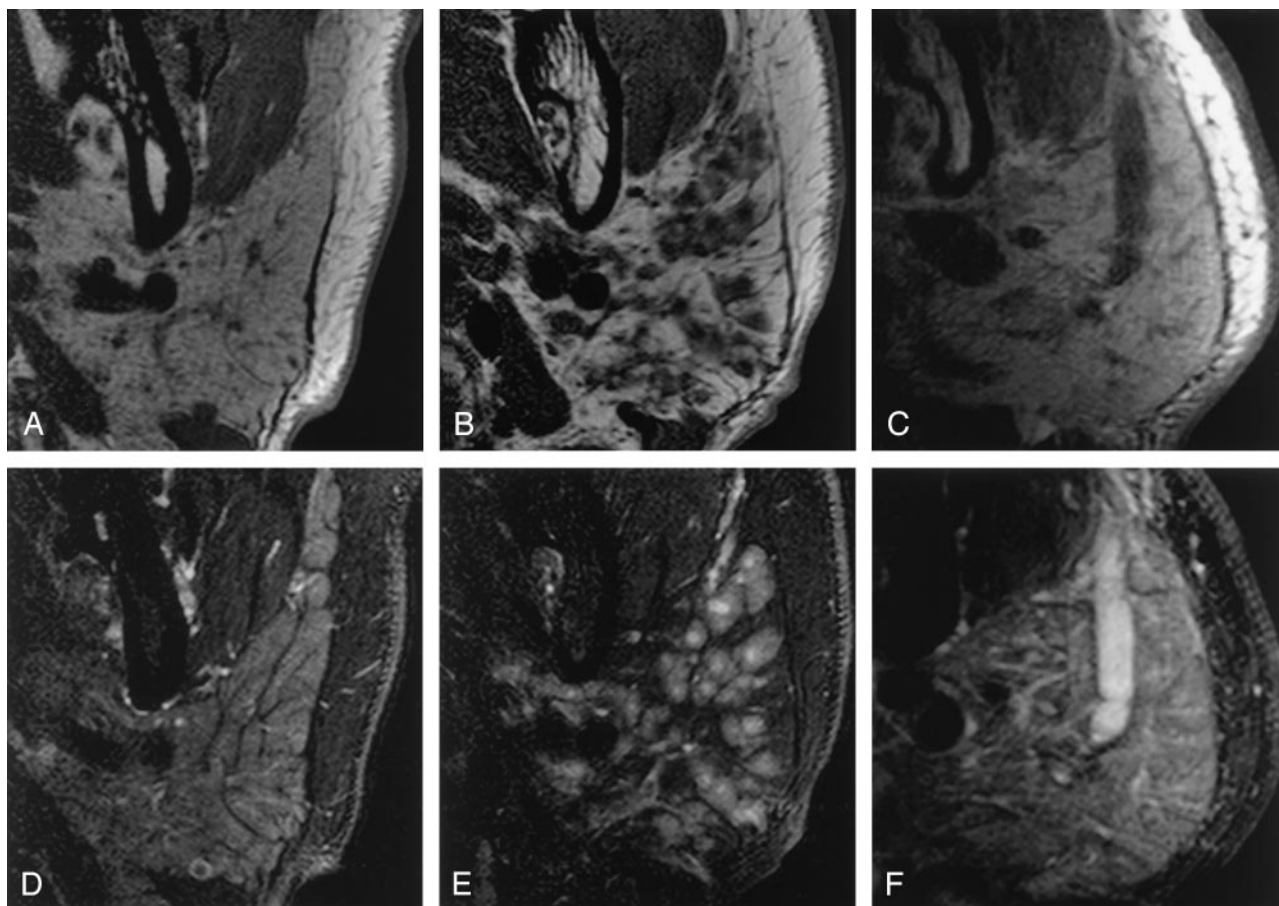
Characteristic MR imaging features of the parotid glands.
